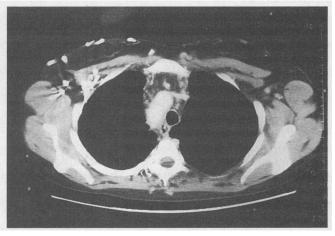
A chest computed tomographic (CT) scan April 1989 shows compression of the superior vena cava and streaky fibrofatty mediastinal densities suggestive of fibrosis. Clearing of the mediastinum compared with the previous chest CT scan and chest wall collaterals are also evident.
